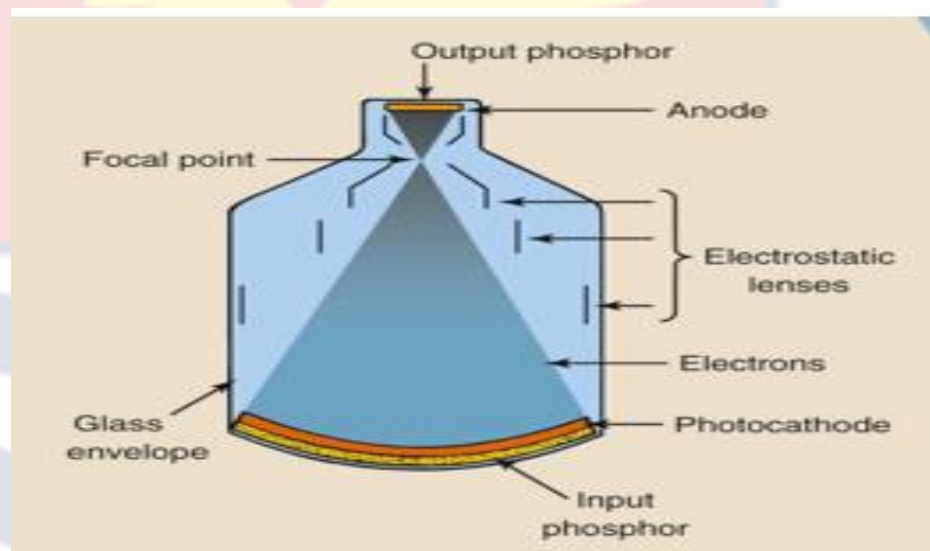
The X-ray image intensifier showing its important components (Risti, n.d.)(Valentin, 2007)
